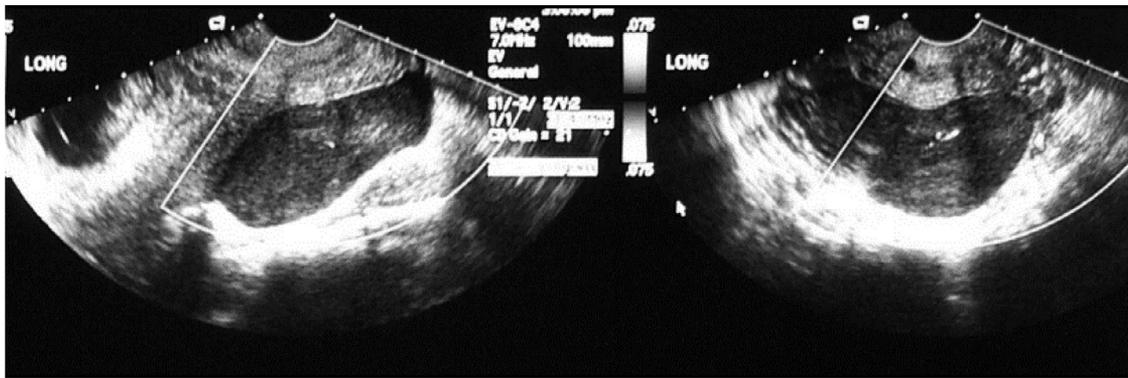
Ultrasound of the adnexa in a first trimester pregnancy showed bilateral solid masses with mild vascular flow. Surgical diagnosis was ovarian lymphoma.
